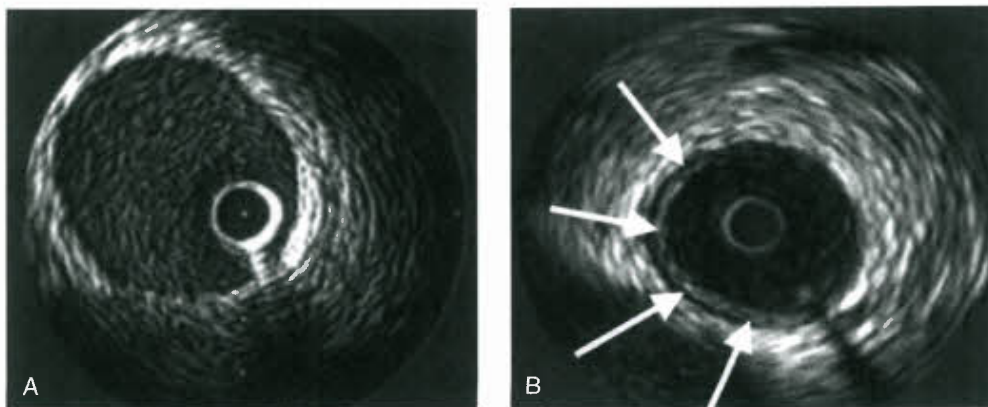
Intracoronary ultrasound image of a normal coronary artery segment (A) and anterior descending segment (B) with intimal proliferation comprising 180° of the vessel circumference (arrows indicate intimal thickening).
